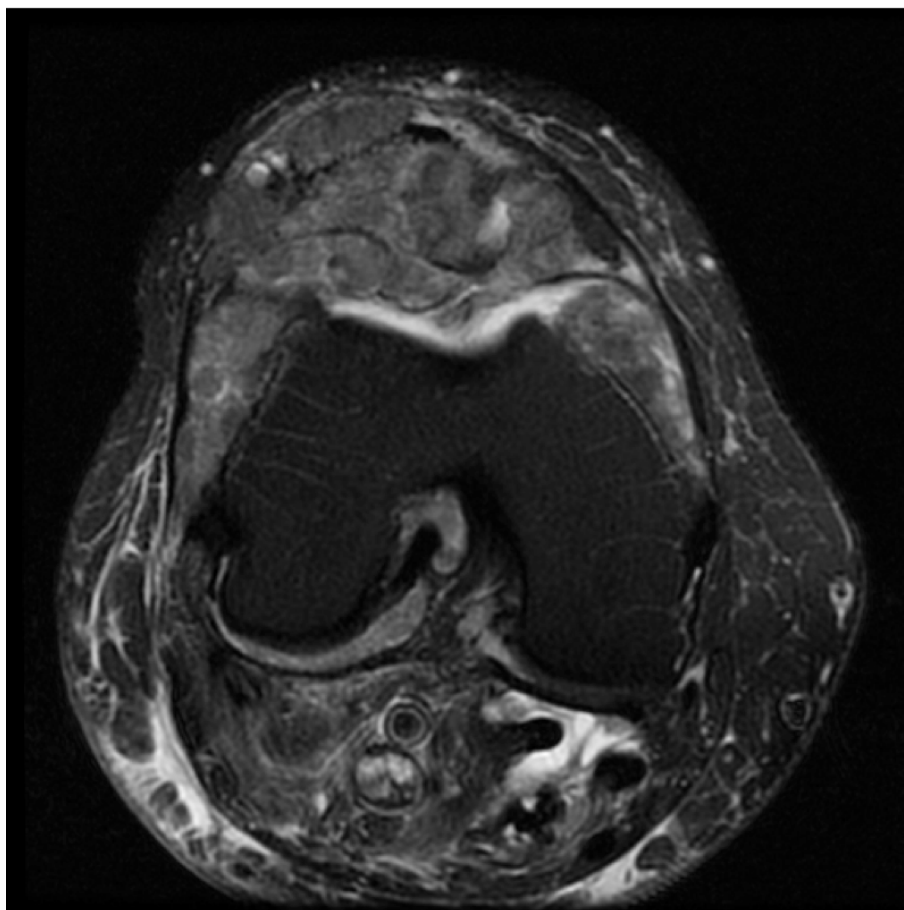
MRI of right knee: Axial T2-weighted image of right knee demonstrated normal synovium replaced with heterogeneous, high signal intensity mass.
